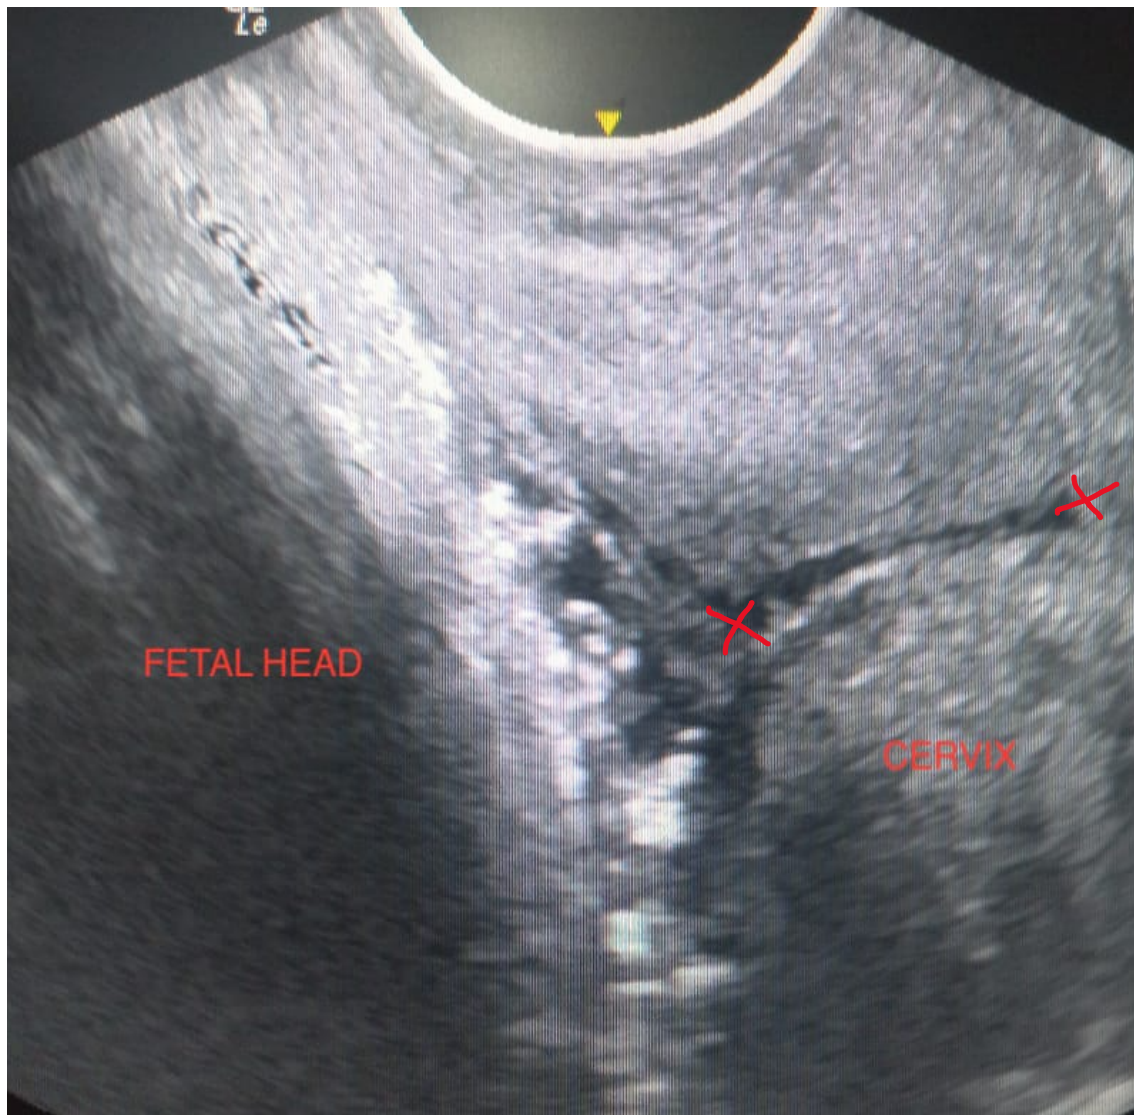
Transvaginal ultrasound image of the cervix showing correct placement of cursors for the measurement of the cervical length (credit: image of a participant of the study)
